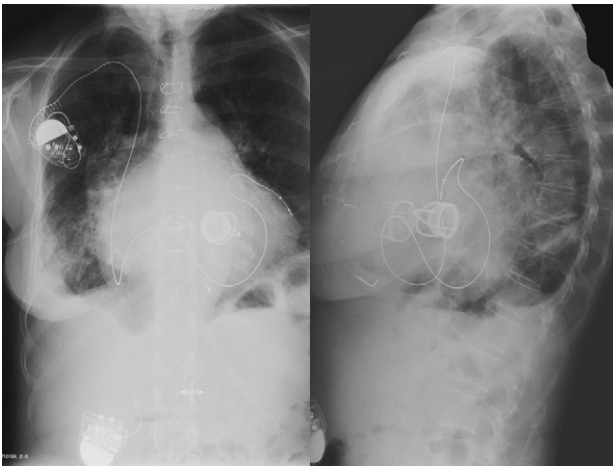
Chest X-ray. Note the previous pacemaker with epicardial leads and the left ventricular stimulation without the need to cross the tricuspid prosthesis.
